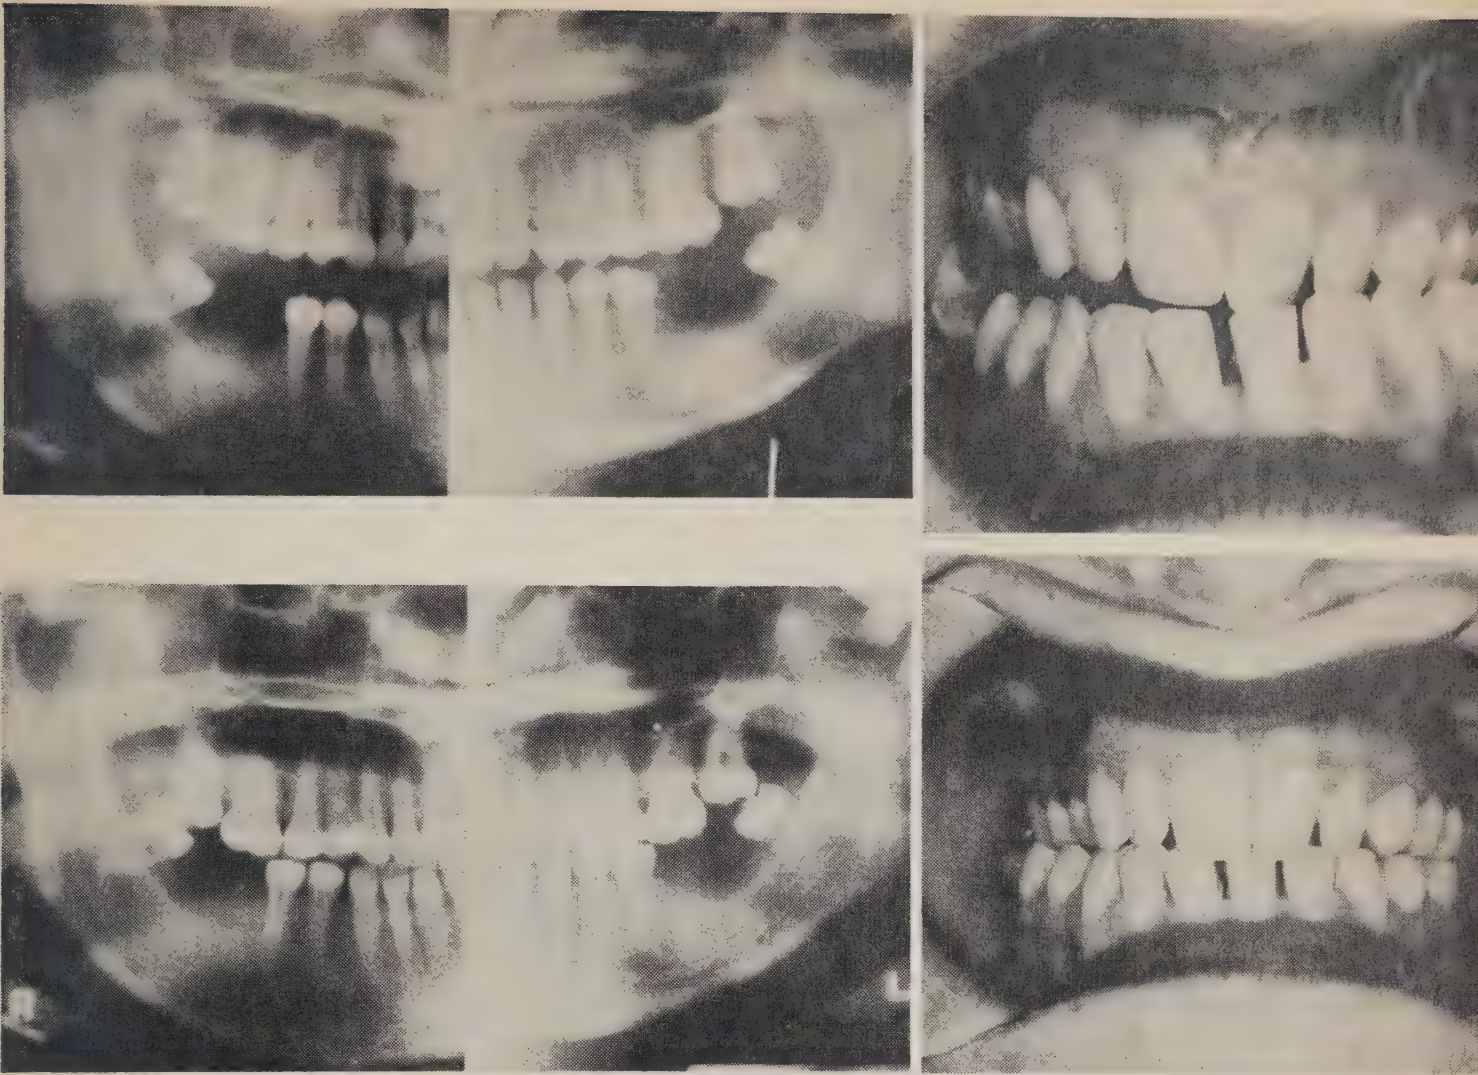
Unilateral prognathism with contralateral crossbite and downward bowing of the affected side. Left: pre-operative and postoperative panoramic radiographs. Right: pre-operative and postoperative occlusion.
